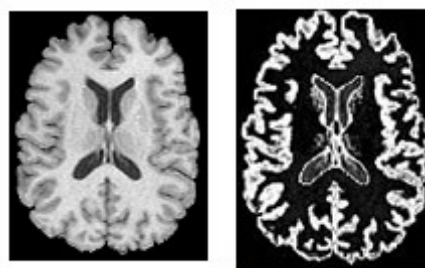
Original MRI image Figure 2. Image after Cluster 1
